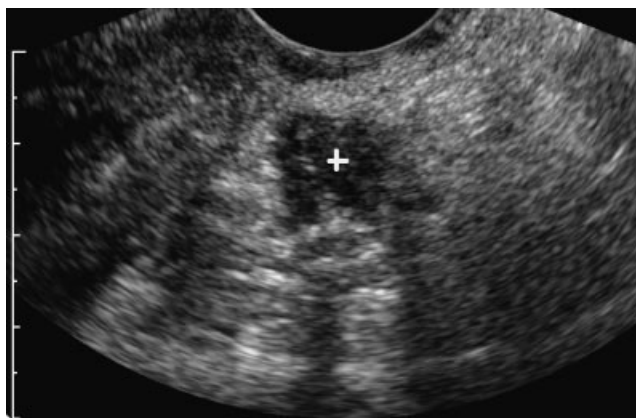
Transverse transvaginal ultrasound image of the posterior compartment of the pelvis, beside the uterus. A small (12 mm mean diameter) nodule of deep infiltrating endometriosis of the left uterosacral ligament is shown (+).
